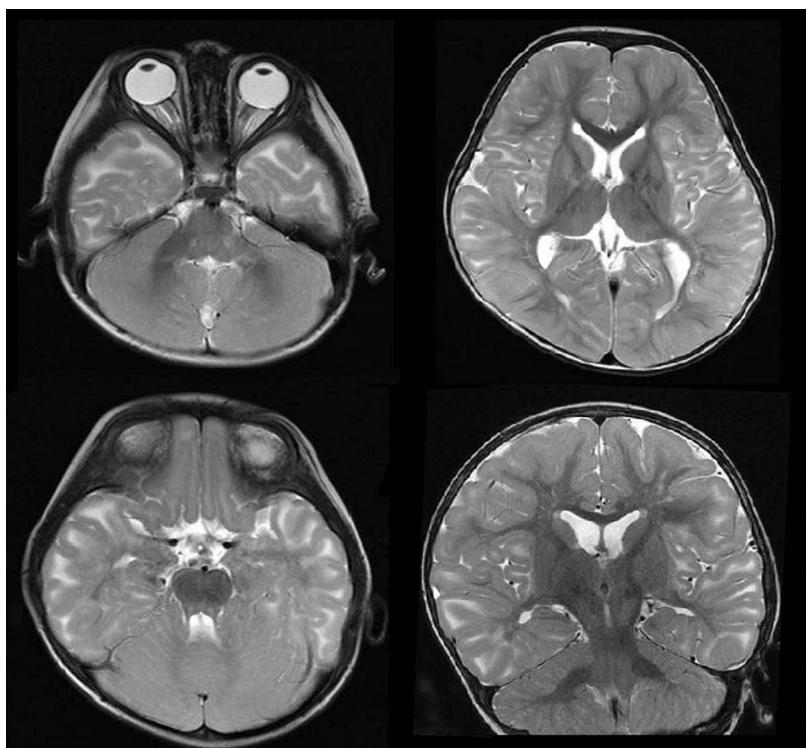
Brain MRI shows bilateral hypersignal intense subcortical white matter regions in the frontal, temporal, and parietal lobes on T2-weighted images, which were not yet associated with cystic changes.
